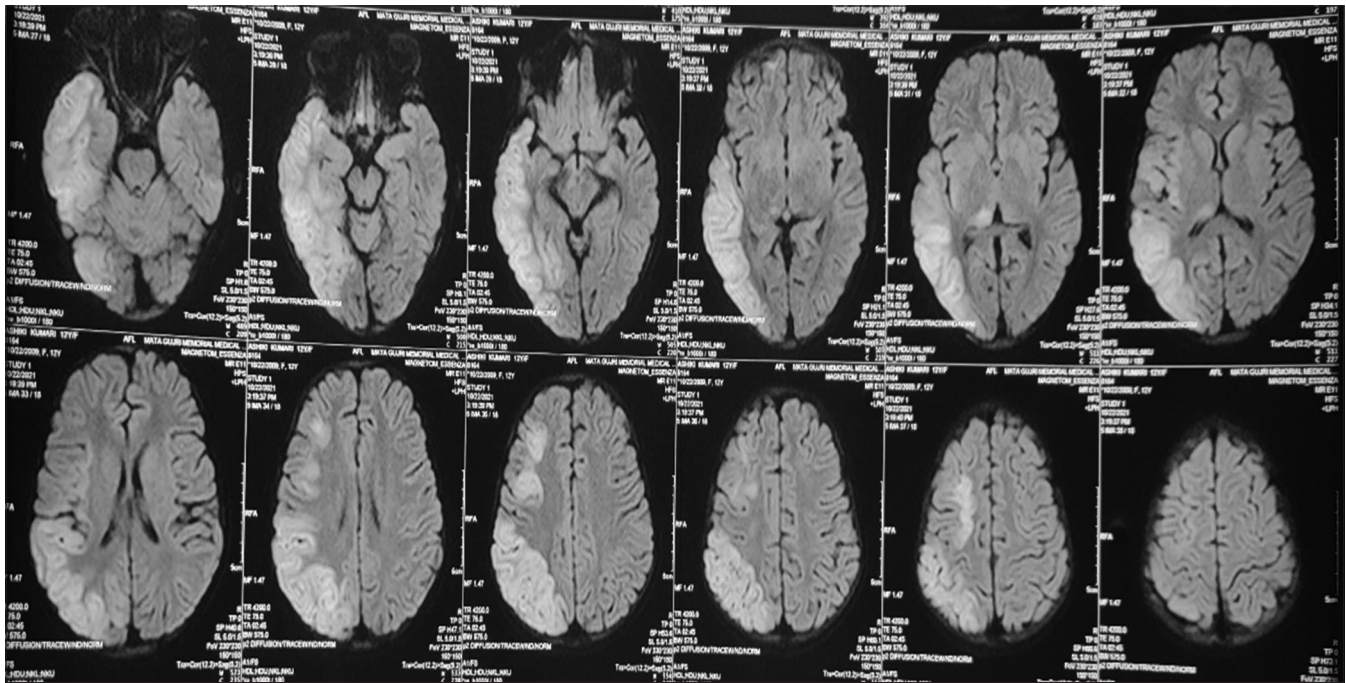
MRI brain showing ADEM like feature in MIS-C^[26]
